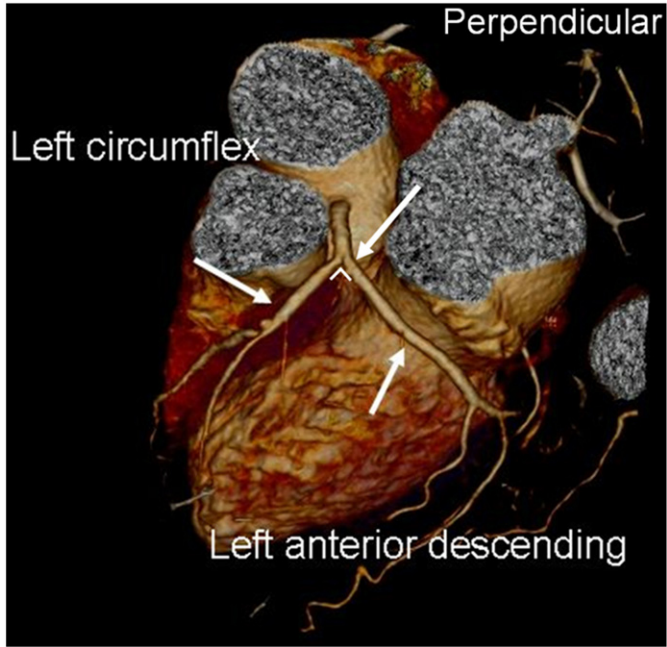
3D CT visualization of a normal left coronary artery with side branches in a patient with suspected coronary artery disease.
